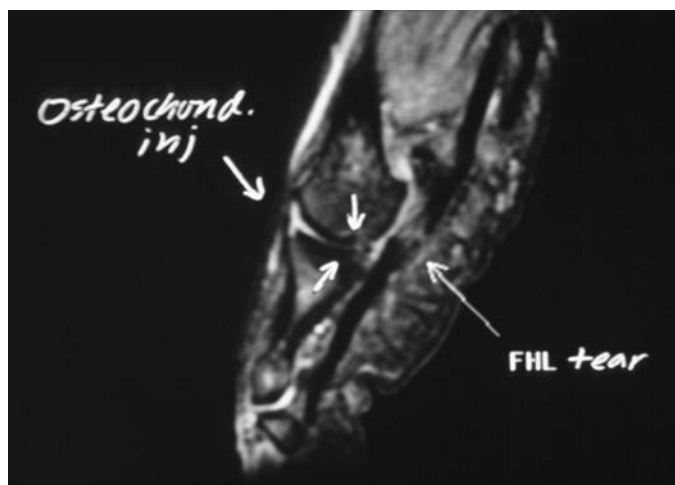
Magnetic resonance imaging notes injury to bones and soft tissue. (From Watson TS, Anderson RB, Davis WH: *Foot Ankle Clin.* 2000;5:698.)
